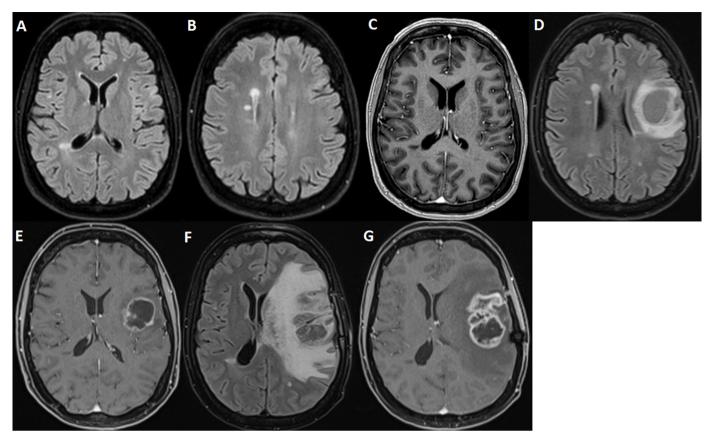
Brain MRI. Axial T2 fluid attenuated inversion recovery (A,B) and T1 post-contrast (C) images performed 5 months (May 2018) before the diagnosis of glioblastoma, and showing no evidence of malignancy. Axial T2 fluid attenuated inversion recovery (D) and T1 post-contrast (E) images of the tumor at initial presentation (October 2018). Axial T2 fluid attenuated inversion recovery (F) and T1 post-contrast (G) images of the tumor 3 months after diagnosis. Periventricular lesions suggestive of multiple sclerosis can be observed (A, B, D).
